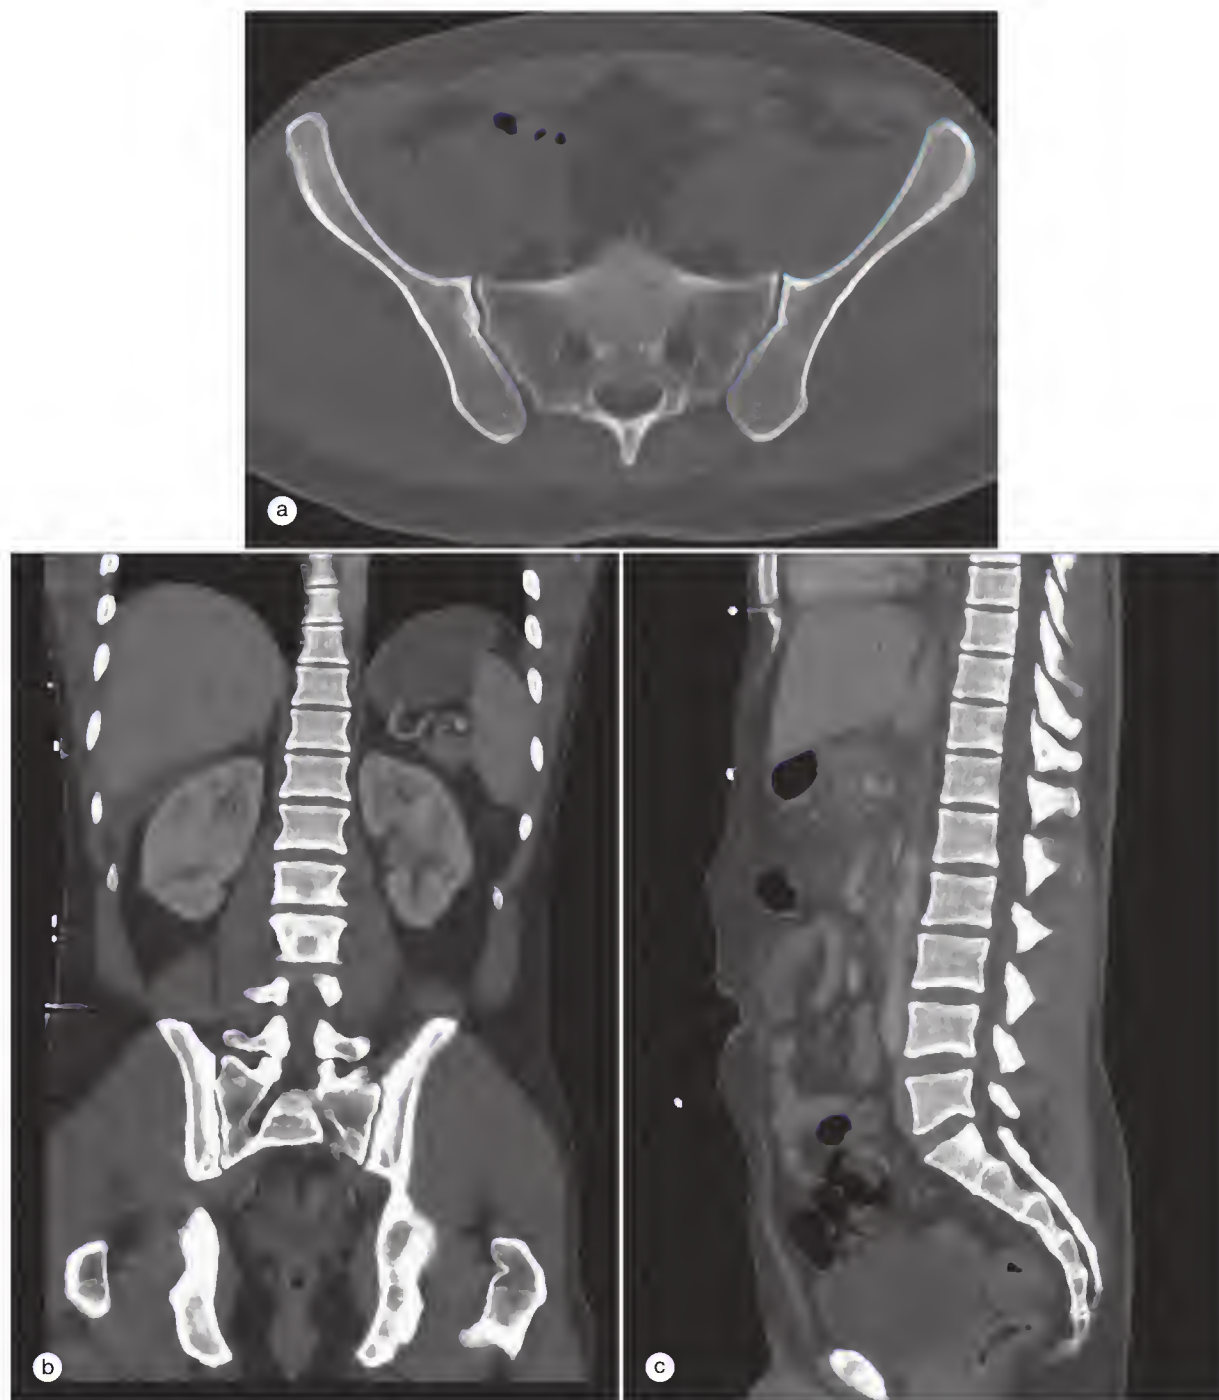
Multidetector computed tomography (MDCT): two-dimensional (2D) and three-dimensional (3D) applications. (a) Axial MDCT image of the pelvis, just one of many thin slices in the original study database for this patient. (b and c) Coronal and sagittal multiplanar reconstruction CT images of the spine and pelvis, respectively, created from original data.
